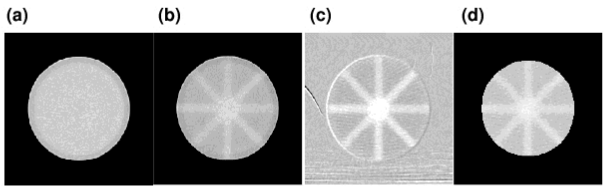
(a) Axial slice of the pre-irradiation, (b) axial slice of the post-irradiation, (c) subtracted CBCT image, and (d) the dosimeter after applying a mask to eliminate the background.
